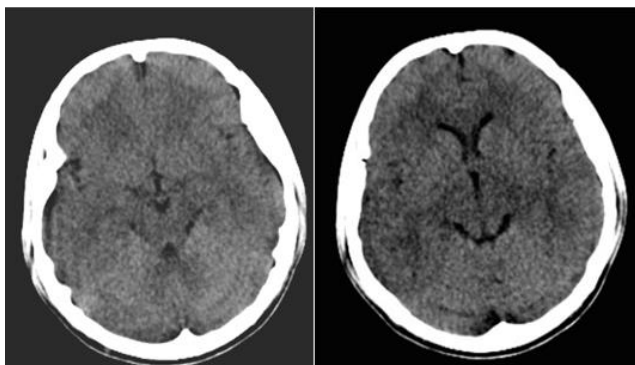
Brain CT scan of patient before hemodialysis. [↑](#)
